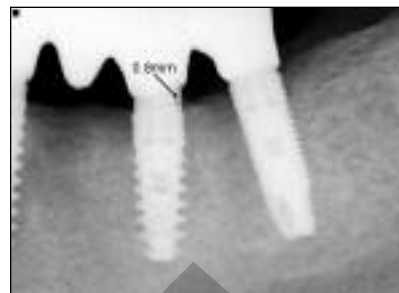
Crestal bone level recorded on digital radiographs mesially and distally at the implant neck.
